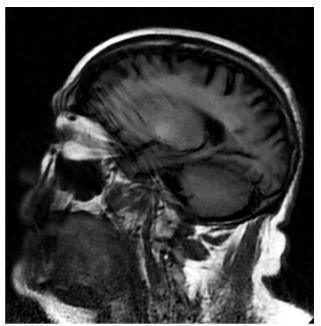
The second case sagital section on T1 of the MRI.
